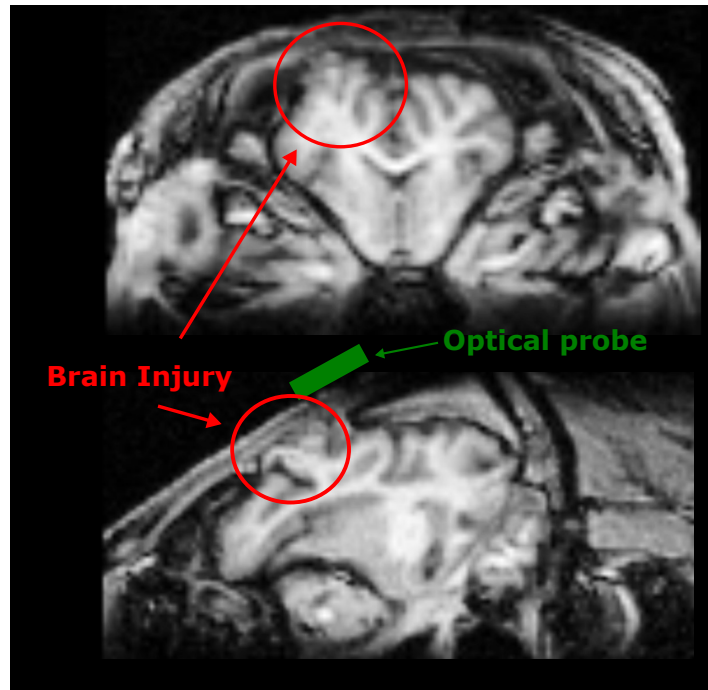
An exemplar structural MRI image collected at 24 hours post injury, revealing significant brain contusion and injury at the injury location (red circle). Here, we also represent the approximate location of the optical measurements (in green); to avoid the cranial incision we always placed our optical probes in a region posterior to the injury site.
